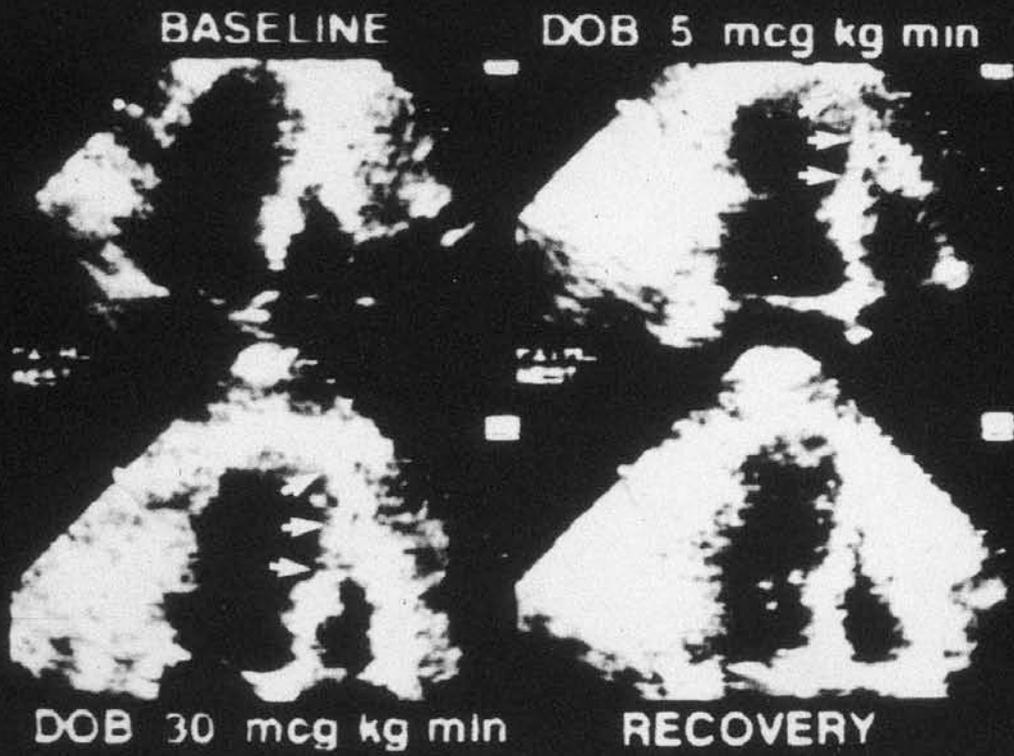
End-systolic echocardiographic frames at baseline and during, low- and high-dose dobutamine infusion, as well as 10 minutes following dobutamine infusion, in a patient with a mid-left anterior descending coronary artery stenosis. Note the development of significant hypokinesia in the mid- to distal septum and apex (arrows), with improvement during recovery. DOB=dobutamine.
